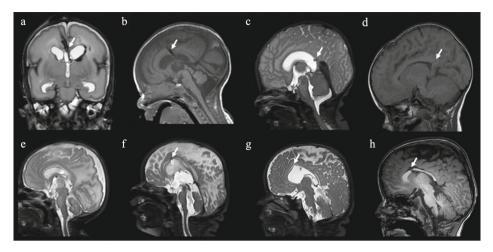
MRI findings of three cases with white arrows pointing to the lesions in each image. Upper panel (a and b) shows a 30^{0/7} preterm infant with PHVD following reservoir insertion. a) Coronal T2-weighted MRI scan demonstrates corpus callosum injury (arrow) following reservoir insertion; b) Parasagittal T1-weighted image shows piercing injury to the corpus callosum; upper panel (c and d) shows a 29^{3/7} preterm infant with PHVD following ventriculo-peritoneal shunt insertion c) Midsagittal T2-weighted image shows injury to the splenium of the corpus callosum (arrow) and d) Midsagittal T1-weighted image shows the effect of injury to the splenium of the corpus callosum (arrow) at 2 years of age; lower panel (e - h) shows a 26^{2/7} preterm infant with PHVD following two reservoir insertions e) Parasagittal T2-weighted image shows the intact corpus callosum after the 1st reservoir insertion, f) Midsagittal T2-weighted image demonstrates the piercing injury to the corpus callosum following the 2nd reservoir insertion (arrow), g) Parasagittal T2-weighted image shows apparent corpus callosum injury (arrow) at term-equivalent age MRI, and h) midsagittal T1-weighted image demonstrates piercing injury with a significant gap in the body of the corpus callosum (arrow) at 2 years of age.
